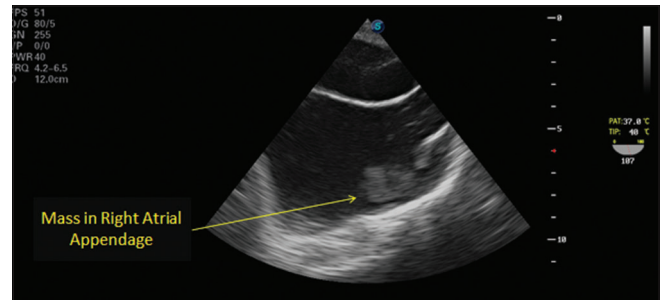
Transesophageal echocardiography view: Mid-esophageal bicaval view showing mass near the inlet of superior vena cava
